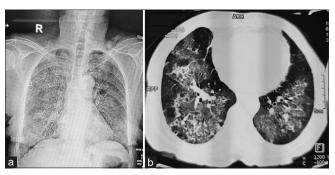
(a) Chest X-ray showing diffuse infiltrates in the bilateral lung. (b) HRCT chest showing diffuse bilateral ground-glass opacities (arrows) with few nodular opacities and tree-in-bud appearance. HRCT: High-resolution computed tomography
